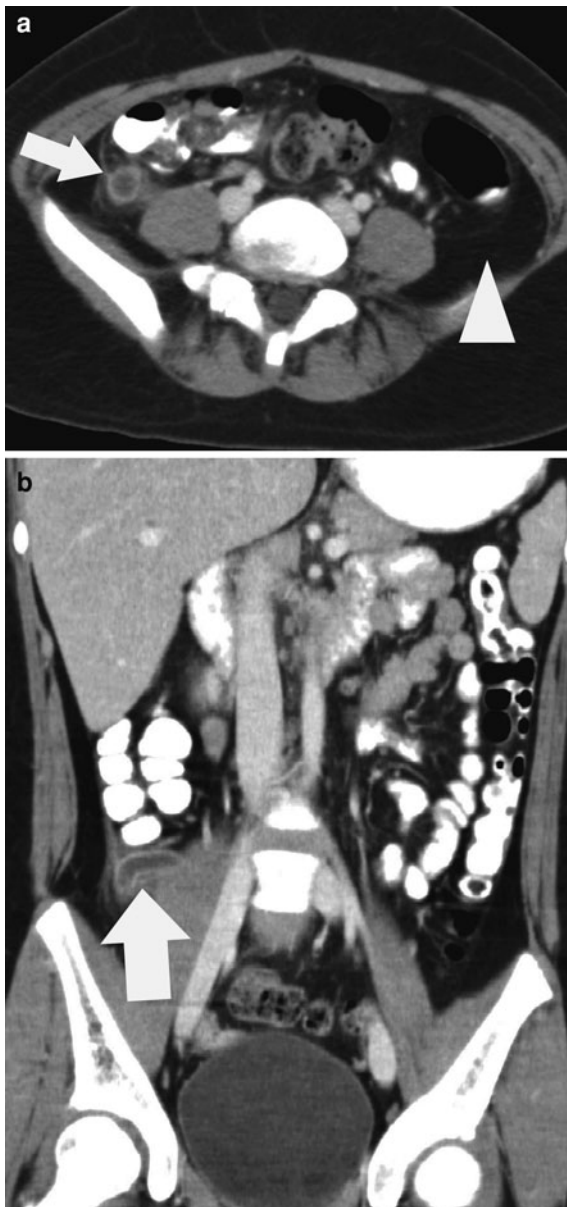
Appendicitis in a 10-year-old-female with abdominal pain. a Axial contrast-enhanced CT demonstrates an enlarged (>6 mm), enhancing appendix with surrounding periappendiceal inflammatory fat stranding (*arrow*) posterior to the cecum. Note normal fat in the left flank (*triangle*). b Coronal reconstructed image confirms an enlarged appendix with periappendiceal fat stranding (*arrow*)
